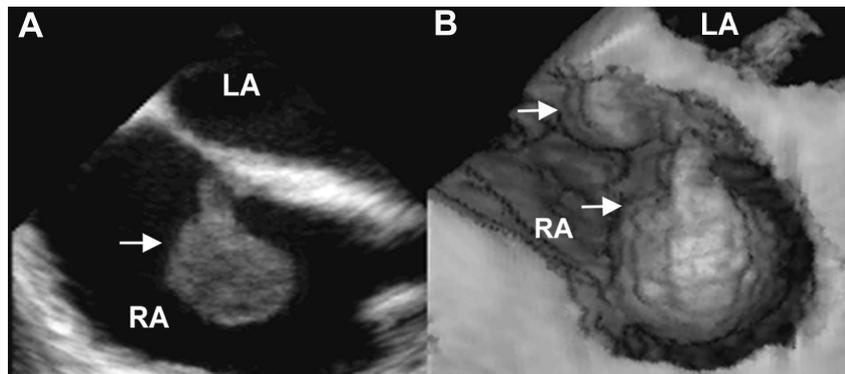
A. Right atrial lymphoma visualized by two-dimensional imaging; and B. three-dimensional image reconstruction. The smaller part of the lymphoma was overlooked and the attachment site not adequately depicted by conventional echocardiography. Moreover, two-dimensional echocardiography is misleading, suggesting that the mass is attached to the oval fossa and may be a myxoma. LA = left atrium; RA = right atrium; →, lymphoma growing from the transition between right atrial roof and interatrial septum into the right atrium.
